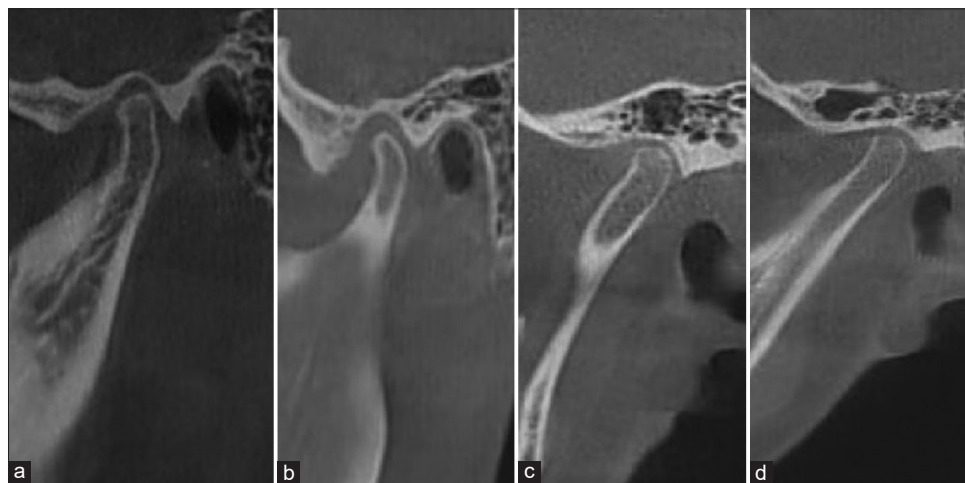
Sagittal CBCT images of different grades of pneumatized articular eminence. (a) Grade 0, (b) Grade 1, (c) Grade 2, and (d) Grade 3. CBCT: Cone-beam computed tomography.
